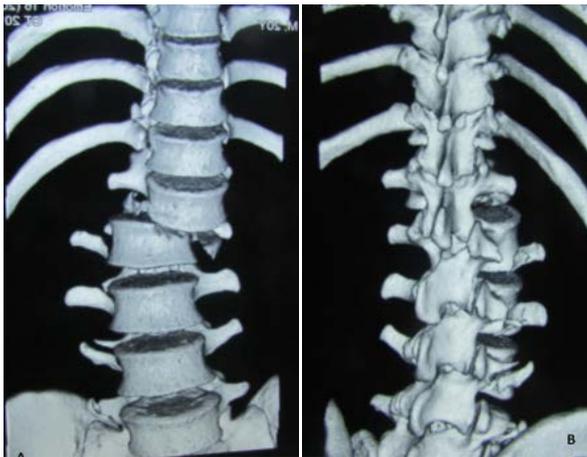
CT of the dorsal spine highlighting a fracture-bursting of T4 and T5, posterior distraction and translation.
